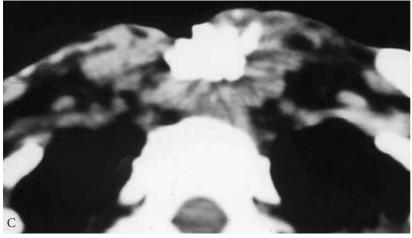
Laryngotracheal and cervical esophageal stenosis due to excessive dose of radioactive iodine used to treat Graves' disease. A, Densely calcified thyroid gland. The larynx is stenotic and the proximal trachea obliterated. B, Lateral cervical view shows calcification in the thyroid, a distorted airway, and a stenotic esophagus. C, Computed tomography scan shows the calcification plus dense fibrosis encasing the trachea and esophagus. The induration involved the carotid arteries and internal jugular veins. Treatment required cervicomediastinal exenteration with mediastinal tracheostomy, colonic substitution for the esophagus, and omental advancement. Primary healing was achieved. even if healing could have been obtained. A tracheal "button" distal to the stenosis was advised in the patient who underwent irradiation in childhood, with subsequent severe laryngeal and upper tracheal stenosis.
